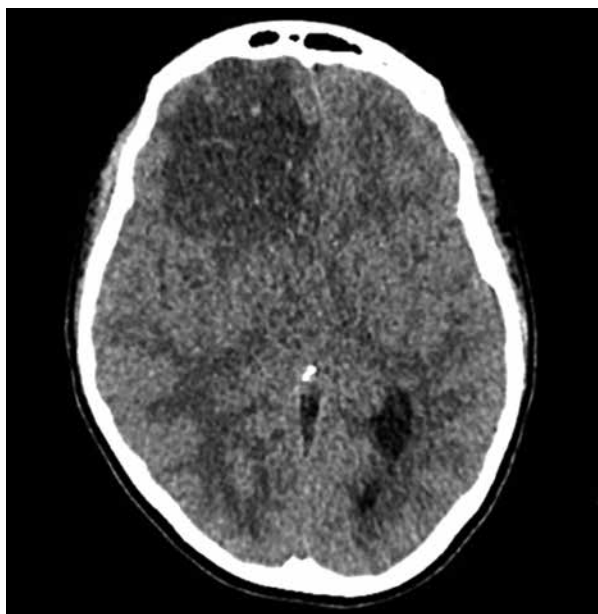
First computed tomography imaging after stroke, 2021 October 10th. Extensive area of intracerebral haemorrhage in the right frontal lobe accompanied by oedema of the surrounding brain tissue
